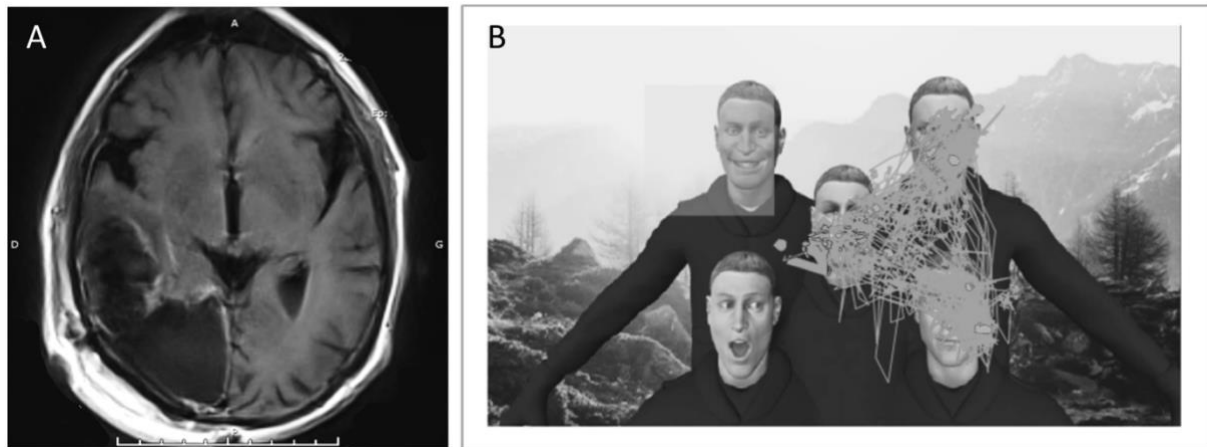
A. Post-operative MRI of a malignant right occipital glioma The patient presented homonymous hemianopia and unilateral neglect. B: Bedside TANGO test: example of the eye tracking feedback (cumulative view of 10 tests) received by the neuropsychologist. The patient was asked to determine the emotion expressed by the face looking at him/her (the upper left face, square). The eye-tracking data recorded for the patient (lines) showed that he was unable to direct his attention to the left side.
